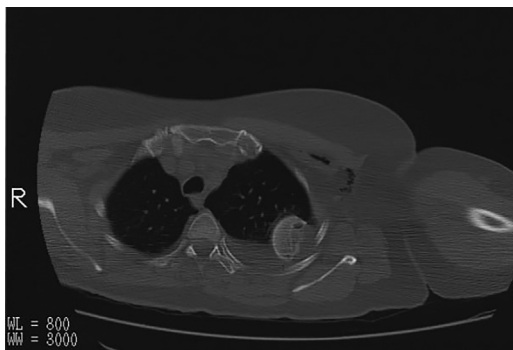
CT-scan showing the intrathoracic localization of the humeral head.
